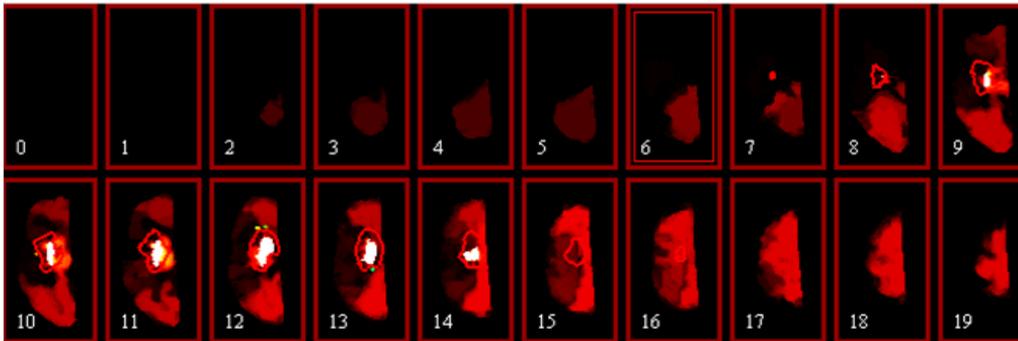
PM* of multi-parameters: *TTP*, *MTT* and *DWI* for 20 slices with reference segmented results at days 30 (Patients171).
